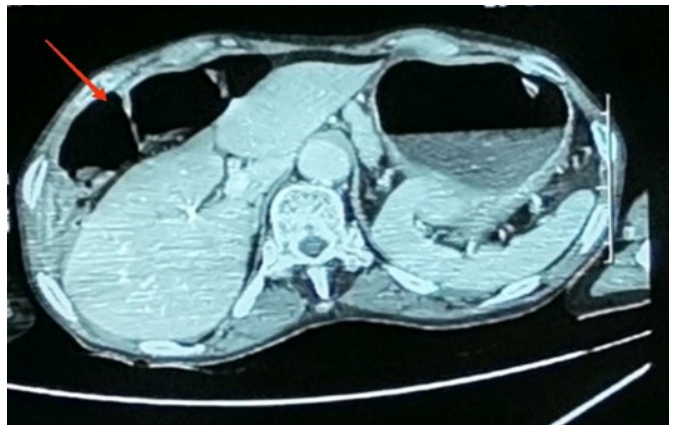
an abdominal CT scan slide showing the Chilaiditi syndrome
